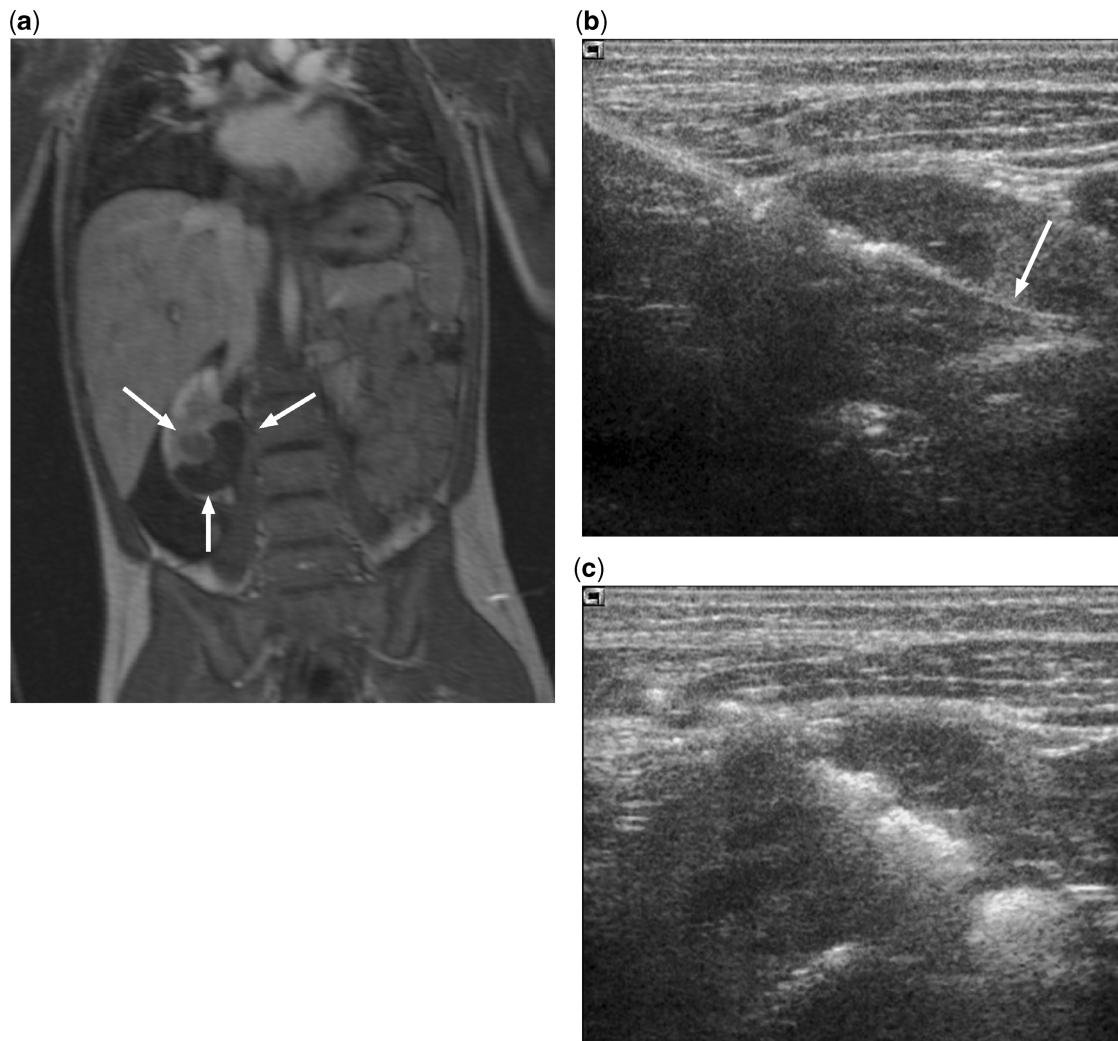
Ultrasound-guided percutaneous biopsy in a 4-year-old girl with rhabdoid tumour of the kidney. (a) Contrast-enhanced T1-weighted MR image shows a solid tumour nodule at the periphery of a fluid-filled space in the right kidney (arrows). (b) Transverse ultrasound image shows a 15/16-gauge coaxial biopsy needle (arrow) being advanced to the periphery of the nodule. Old blood was aspirated from the fluid-filled space. Eleven cores of tissue were obtained. (c) The biopsy tract was plugged with absorbable gelatin sponge (Gelfoam, Pharmacia & Upjohn, Kalamazoo, MI, USA) as the outer needle was withdrawn.
